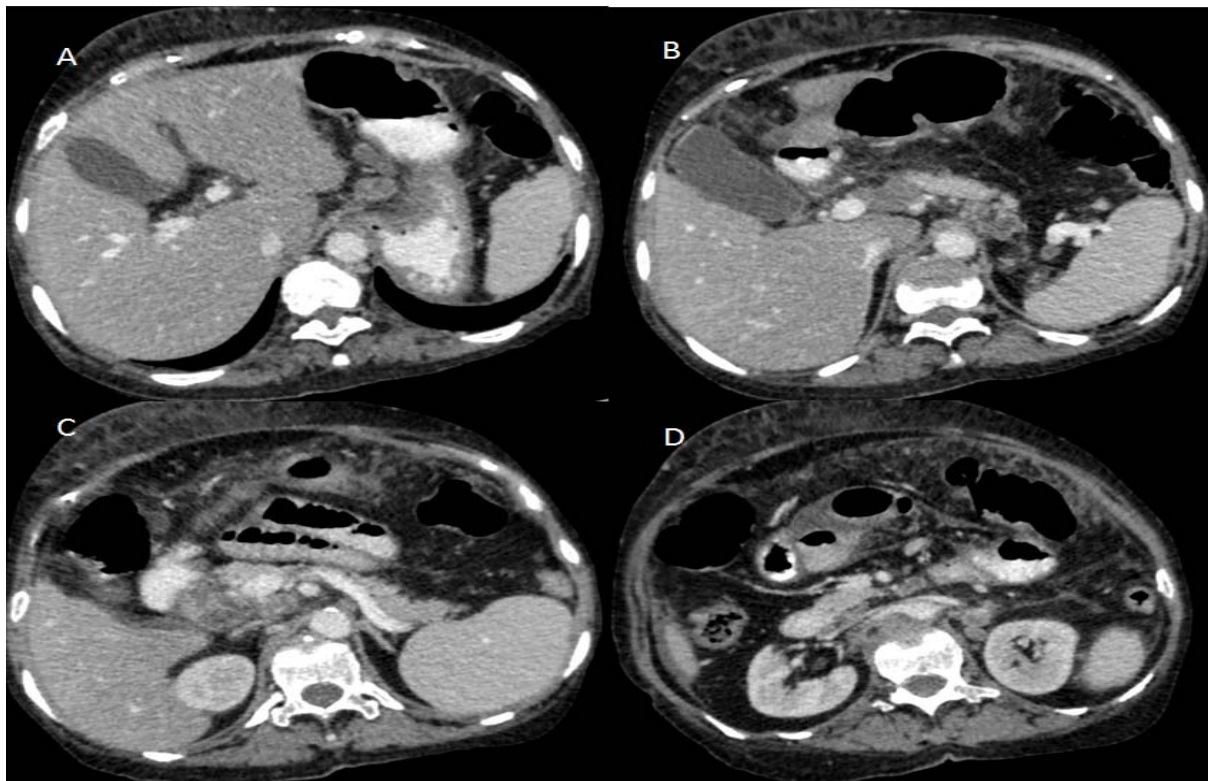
Contrast-enhanced CT scan of the abdomen showing lymph nodes at the celiac axis (A, B), in precaval region (C), in the left para-aortic and preaortic region (D) showing peripheral enhancement with central hypodense areas of necrosis.
